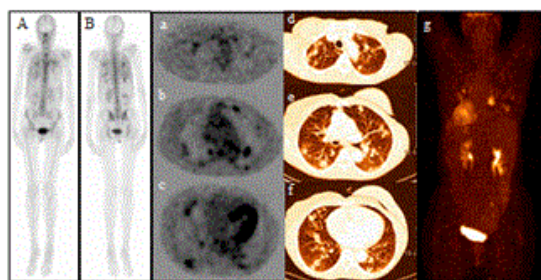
Whole body bone scan and FDG PET/CT images. Bone scan images of 99m Tc MDP demonstrated multiple foci of increased activity in chest with more prominence on the posterior view. A, anterior view, and B, posterior view. FDG PET/CT imaging for restaging demonstrated numerous metabolically active bilateral lung nodules compatible with extensive lung metastasis. There was no evidence of osseous liver or lymph node metastasis. a, b, and c, PET axial views from apex to basal lungs, d, e, and f, hybrid PET/CT axial views from apex to basal lung, and g, maximum intensity projection.
